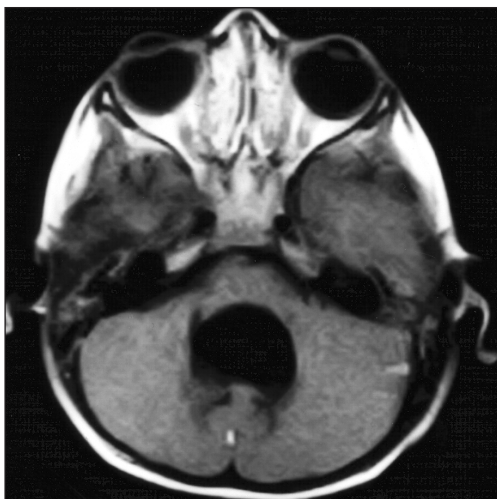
Axial T1-weighted magnetic resonance image show the absence of vermian agenesis and the present displacement in brain stem anteriorly.
